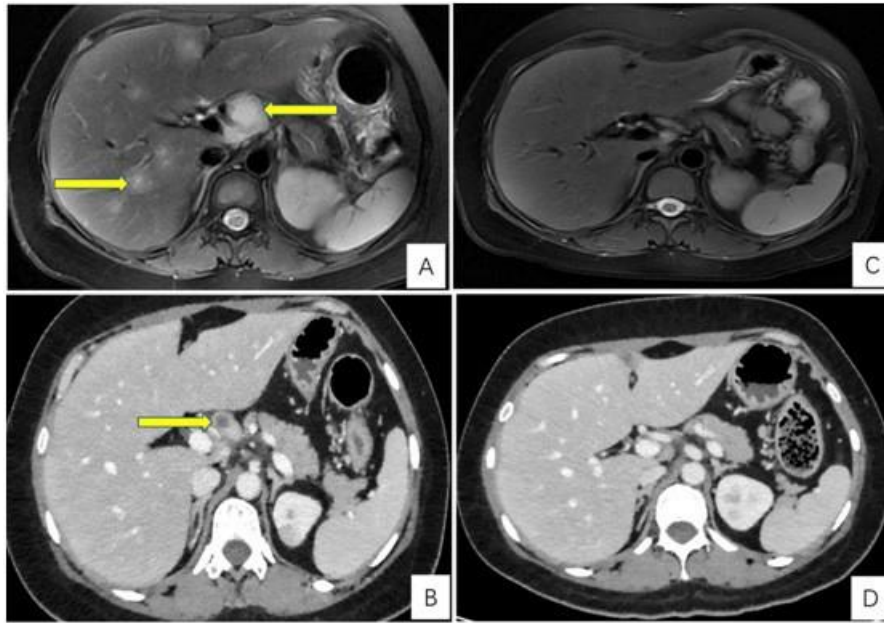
Abdominal radiological images demonstrating hepatic and renal lesions and aseptic abscesses before and after 4 months of treatment. MRI (A, C) and CT (B, D) scan of upper-abdomen showed multiple lesions in liver and kidneys (green arrows) and enlarged abdominal lymph node with central liquefactive necrosis (yellow arrows) at the time of admission (A, B). After treated with vedolizumab, the lesions decreased in sizes (B, D).
